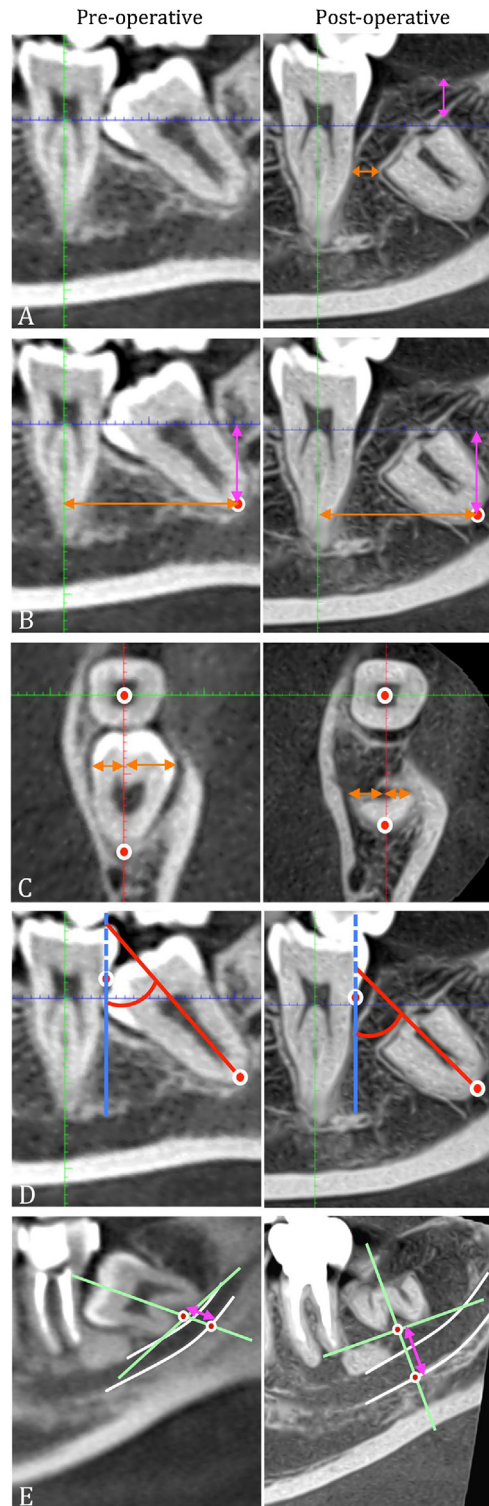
Assessment of root remnants following coronectomy using cone beam computed tomography (CBCT) imaging. (a) The amount of bone superficially to the third molar root was measured as the shortest distance between the coronectomized root surface and the superficial bone crest (purple line). The amount of bone regenerated at the distal aspect of the adjacent second molar was measured as the shortest distance between the third molar root and second molar (orange line). (b) Vertical and horizontal translations were assessed in a sagittal CBCT view. A vertical translation (purple line) was evaluated from the apex of the third molar root to a perpendicular line according to the long axis of the second molar passing through the pulp by comparing pre- and post-operative scans. A horizontal translation (orange line) was evaluated from the apex of the third molar root to the long axis of the second molar. (c) A
